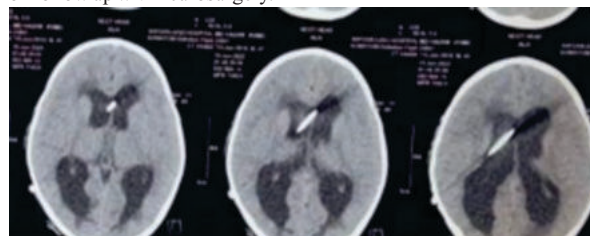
Head CT Showing The Cranial End Of VP Shunt Catheter
